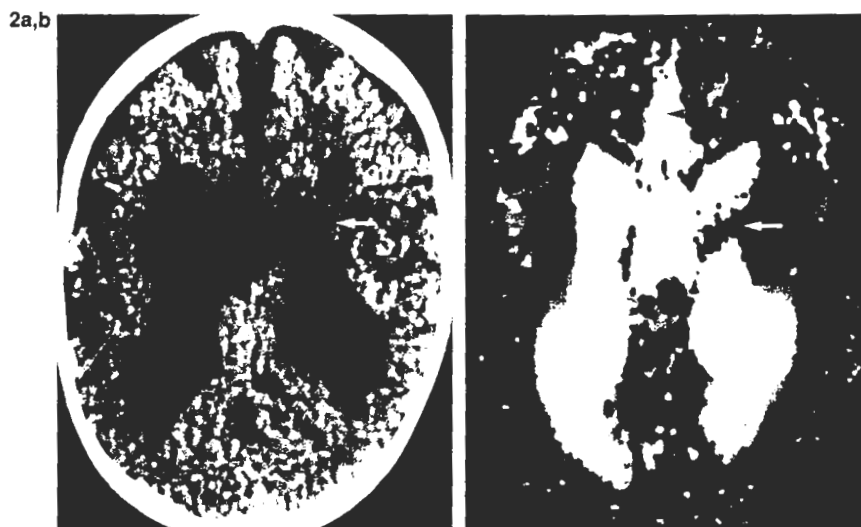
Callosal agenesis in a 6-month-old boy. a: Axial noncontrast CT scan demonstrates callosal agenesis with enlarged, separated lateral ventricles, deformity (white arrow) of the medial wall of the left lateral ventricle, wide interhemispheric fissure containing the falx, and enlarged sulci. b: Reformatted 3D, noncontrast CT scan faithfully reproduces the contour of the lateral ventricles, the defect (white arrow) in the body of the left lateral ventricle, and the position of the falx (black arrowhead) within the widened interhemispheric fissure. The widened sulci are reproduced but are less conspicuous on the 3D image because they merge with the ghosts.
